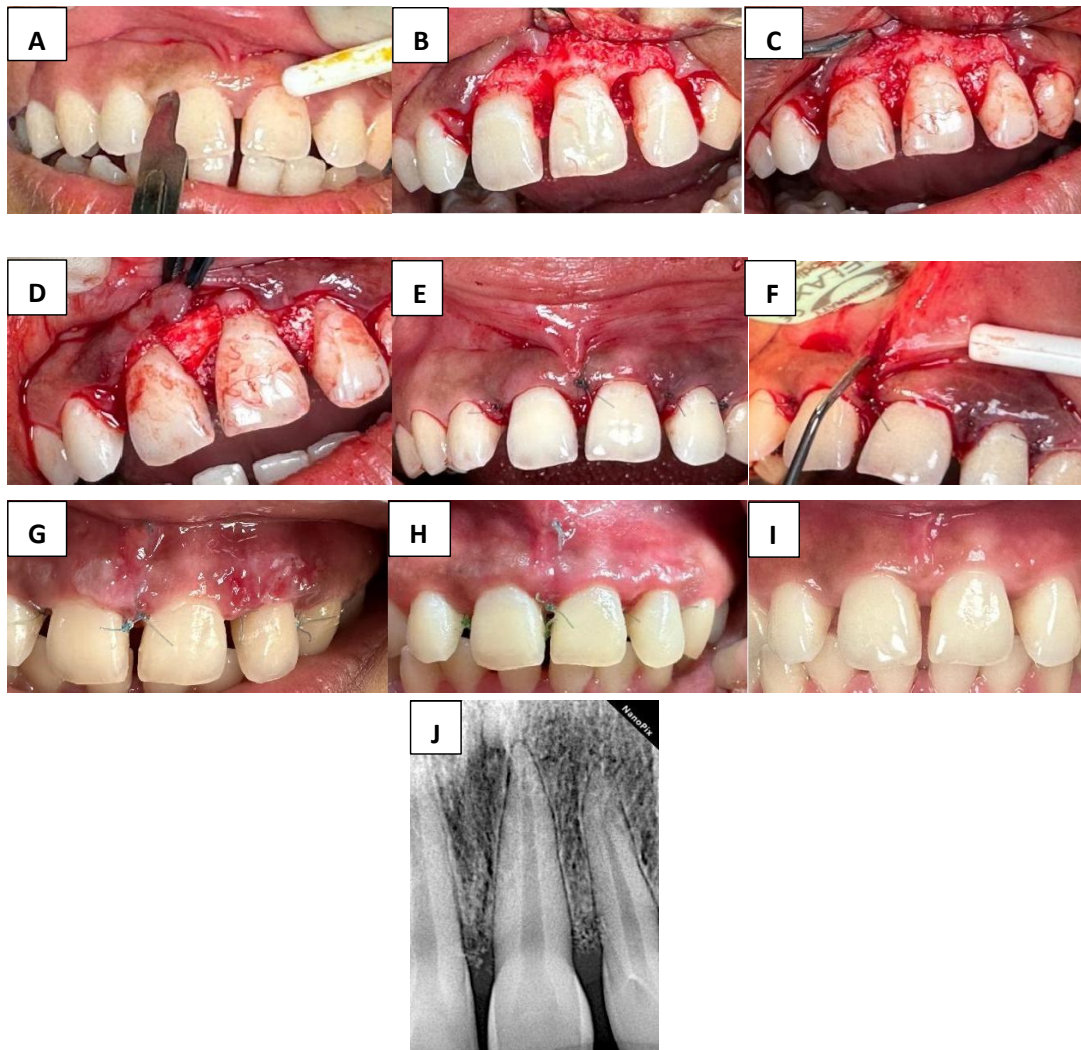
Open flap debridement to gain access. (A) sulcular incision, (B) removal granulation tissue with curettage, then scaling, and root planing, (C&D) GTR was performed using bone graft from alenograft and resorbable collagen membrane to correct the infrabony defect area, (E) Flap fixed with simple interrupted mattress sutures, (F) a frenectomy is also performed to remove tension at the flap closure, (G) Opening of the periodontal pack were removed at seven days post-surgery, (H) Opening of sutures was removed at 14 days post-surgery, (I&J) Control was performed three months post-surgery and periapical radiographs were taken.
